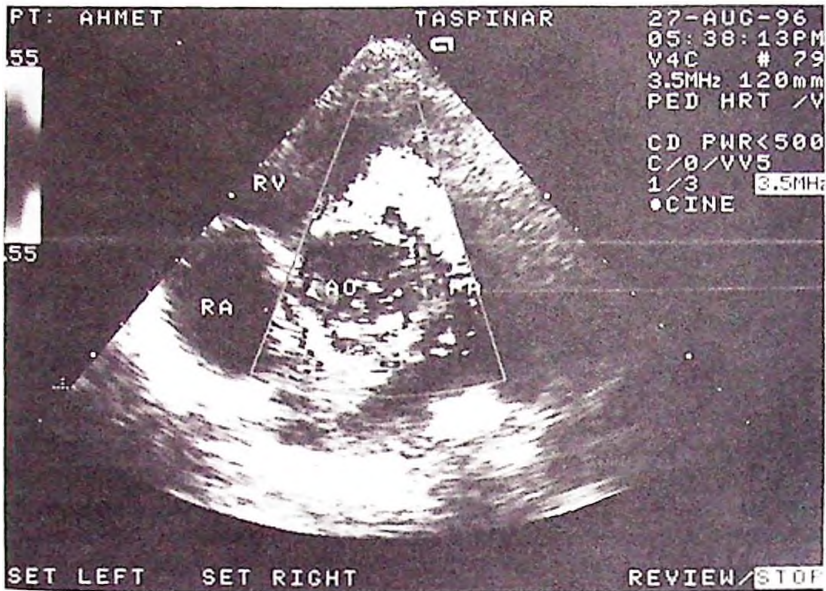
Color flow imaging of the turbulent flow in the right ventricular outflow tract originating from the sinus Valsalva. Aneurysm is seen in the parasternal short axis view of the second patient. RA: right atrium, RV: right ventricle, Ao: aorta, PA: pulmonary artery.
